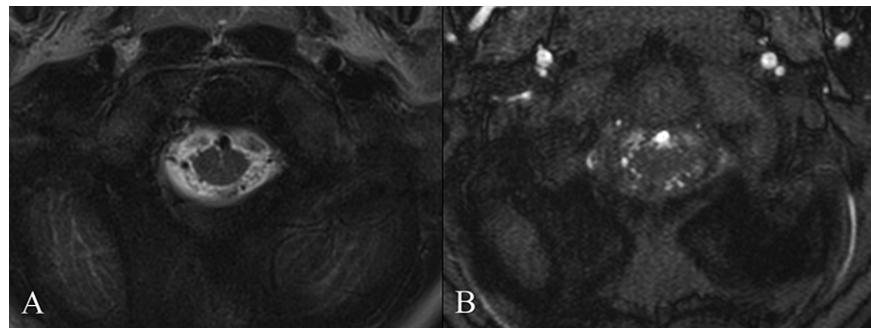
A 2-year-old boy with Keutel syndrome and bilateral vertebral artery occlusions. (A) Magnetic resonance imaging, T2-weighted image, axial plane, showing prominent perimedullary flow voids indicating the presence of abnormal vascular structures at the level of the upper cervical spinal cord. (B) Magnetic resonance imaging, time-of-flight magnetic resonance angiography, axial plane, confirming the upper cervical hypervascularity suggested by the T2-weighted sequence.
